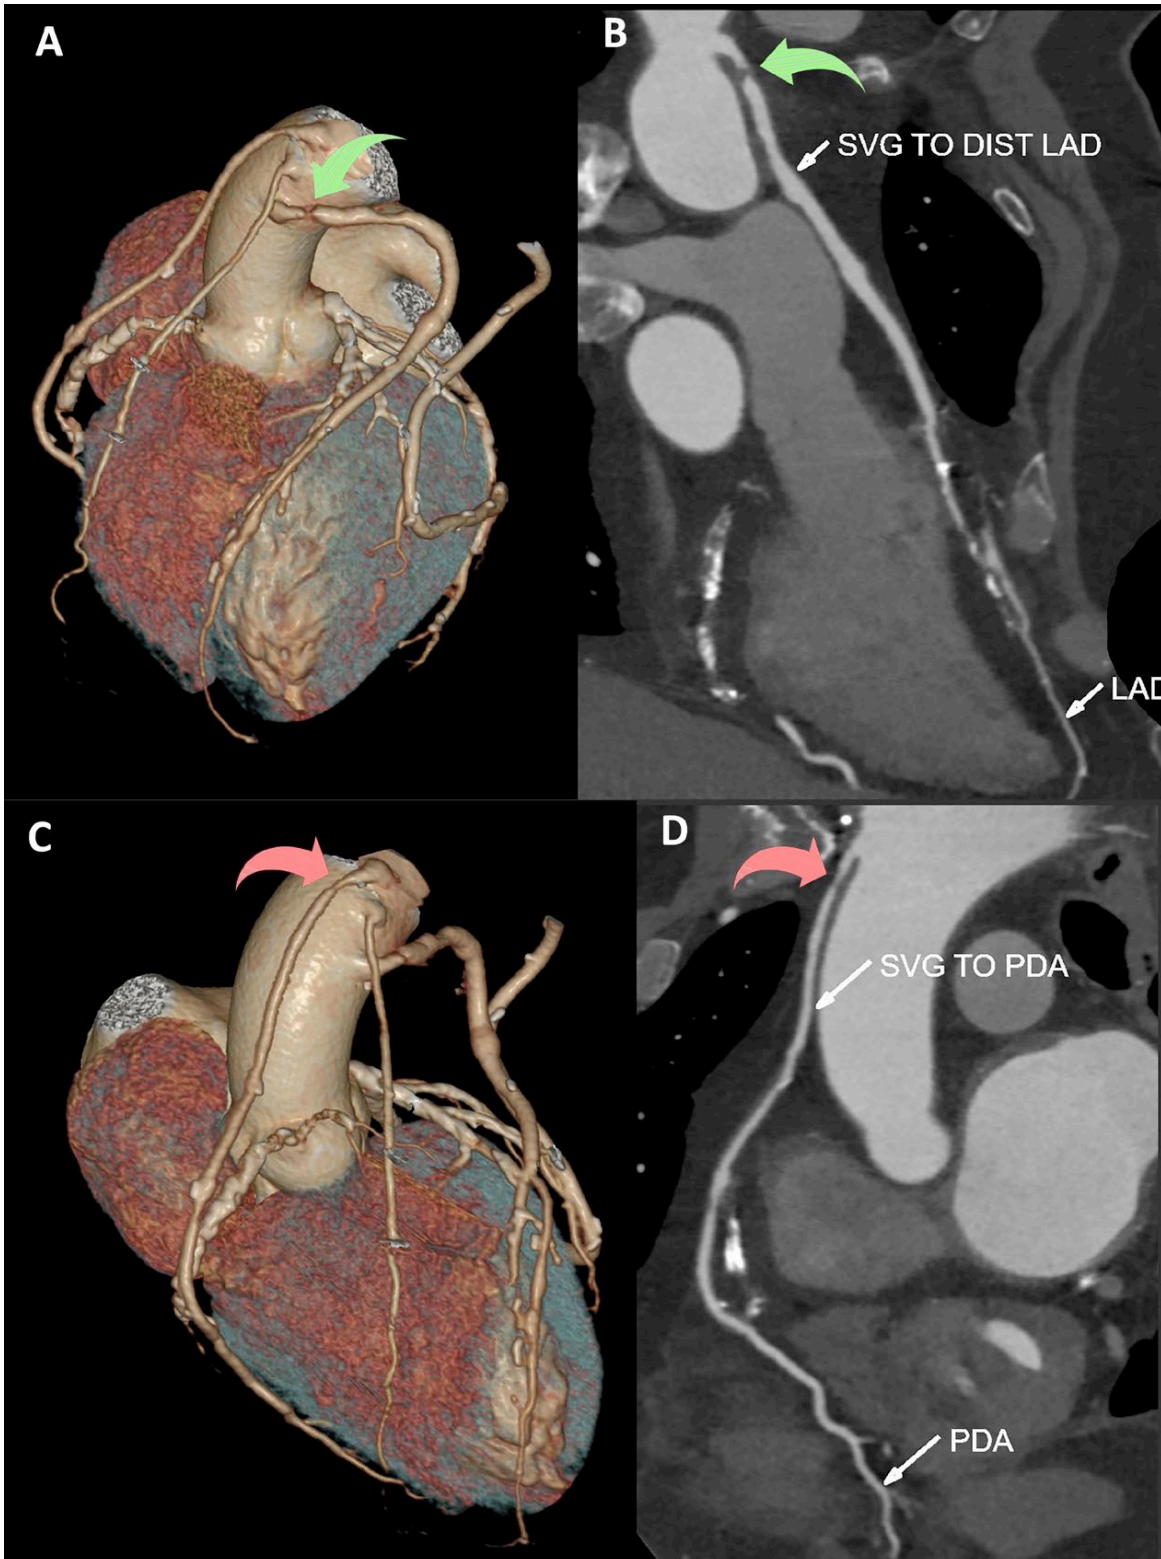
A 67-year-old man 6 years post CABG comes with recurrence of angina. Sequential LIMA to Diagonal and Obtuse marginal as well as saphenous vein grafts (SVG) to LAD, right ventricular branch and right PDA are patent. However, short critical stenosis is seen in the proximal segment of the SVG to LAD (green curved arrow) as well as the SVG to PDA (orange arrow). These were successfully stented. Patient was scanned on a uCT 780 (United Imaging Healthcare, Shanghai, China) 160 slice cardiac CT scanner.
